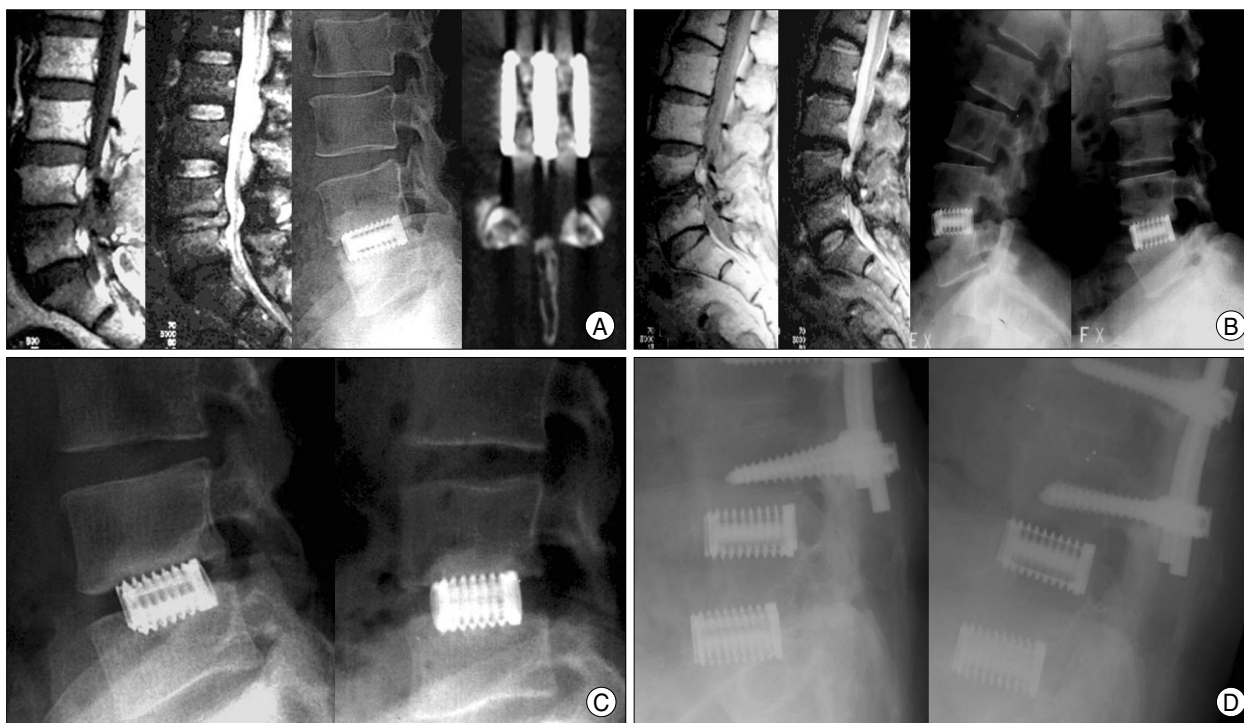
A : Patient with chronic degenerative disc disease with stenosis at L4/5 who underwent posterior lumbar interbody fusion with threaded fusion cages. Magnetic resonance imaging (MRI) also reveals Modic type 1 degeneration at vertebral end plate. Plain X-ray and lumbar CT scan after post-operative 47 months show a posterior bony bridge without traction formation and halo around the cage. This patient is compatible with bony fusion criteria. B : Patient who shows Modic type 3 degeneration at vertebral end plate on MRI. Post-operative 26 months plain film shows instability at flexion/extension view. C : Patient with sclerosis at upper end vertebral plate shows settling of cages and incomplete formation of bony bridge at plain lateral film. D : Post-operative 60 months plain film shows instability and halo around cages at flexion/extension view. These patients are classified as a non-union by bony fusion criteria.
